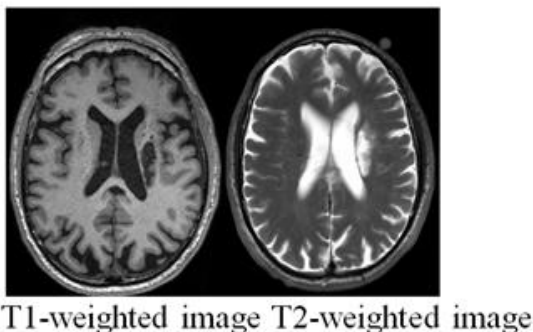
T1-weighted and T2-weighted images in ischemic stroke pathology. T1-weighted image appear hypointense and T2 is hyperintense in ischemic stroke lesion. Images are taken from one of the ischemic stroke patients.
